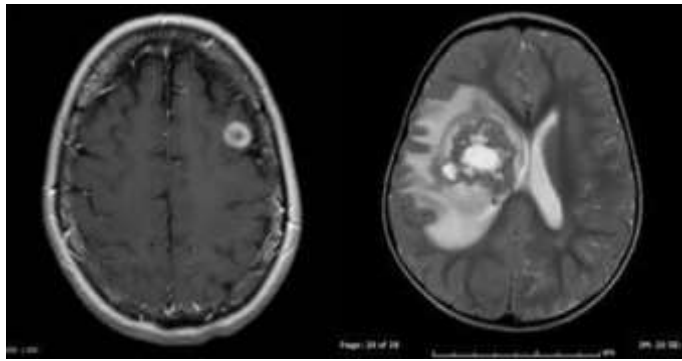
Benign and malignant tumors on MRI
